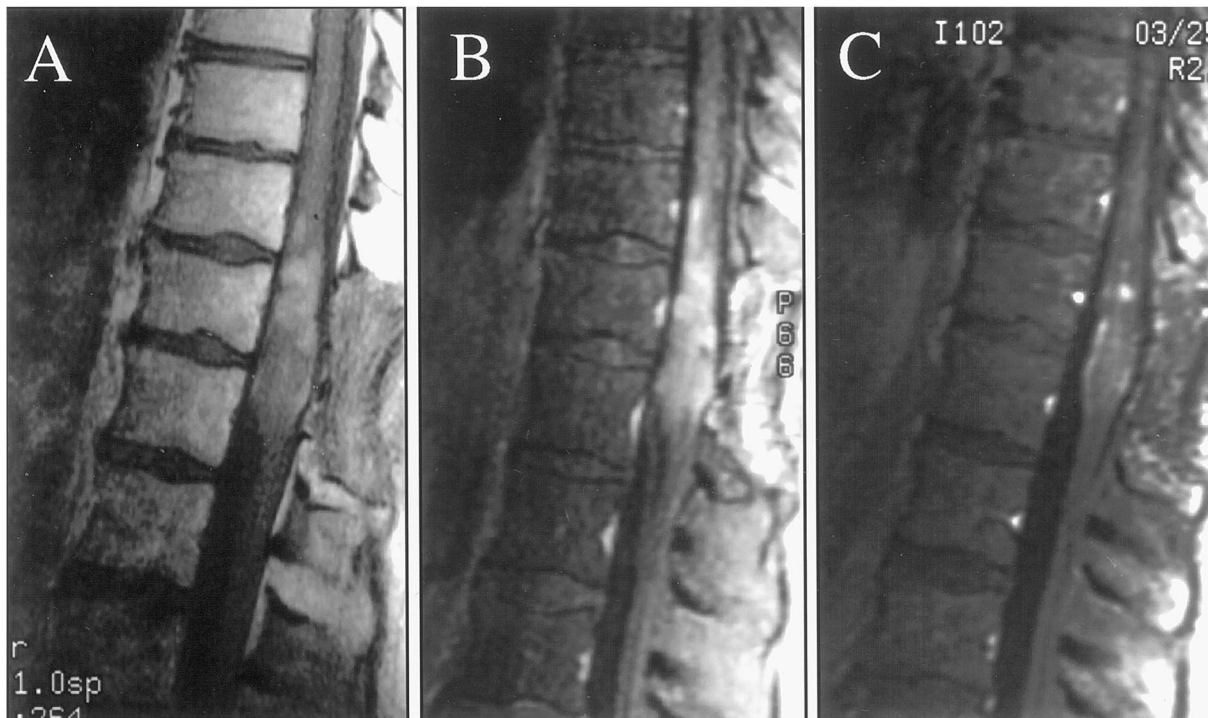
Contrast-enhanced MRI scans of astrocytoma of the conus medullaris. (A) Tumor at the time of progression after irradiation. (B) Clinical progression after four cycles of cisplatin and etoposide. (C) Radiographic and clinical response after seven cycles of PCV.
